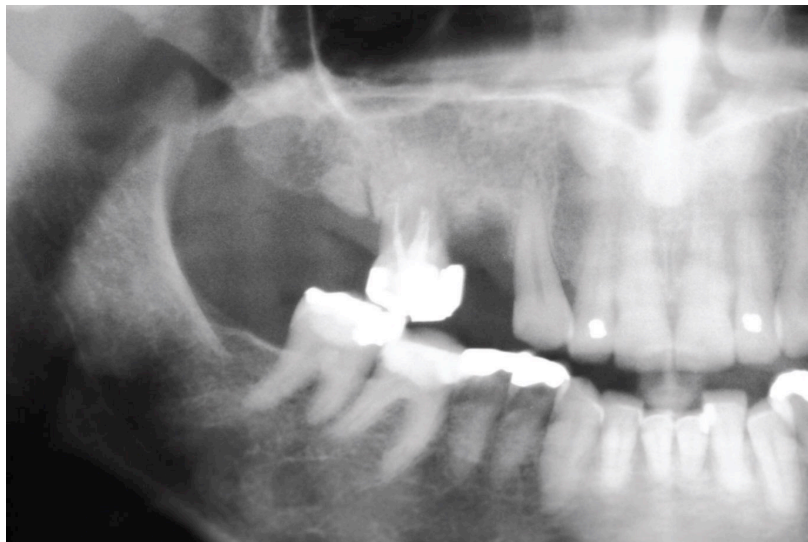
Radiograph shows hopeless upper molar with retained roots both mesial and distal to the tooth
